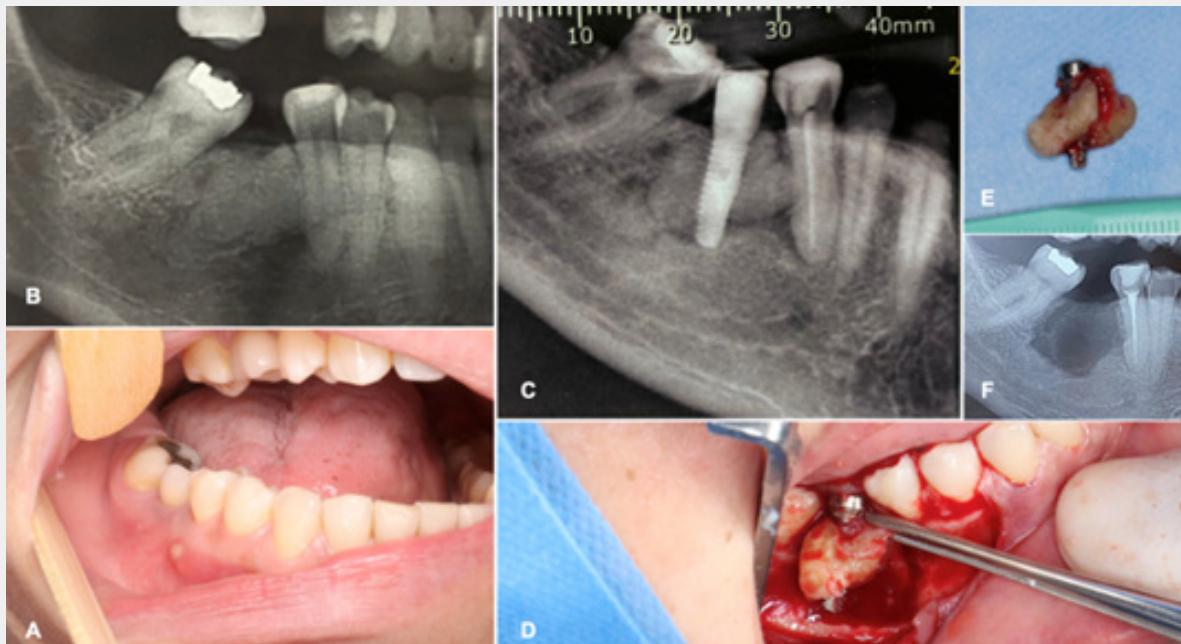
Infected focal COD presenting a gingival fistula. A, Intraoperative fistula located adjacent to the lower right second premolar with purulent discharge. B, Initial panoramic radiograph demonstrating a well-defined, asymptomatic radiopaque lesion in the region where the dental implant (DI) was installed. C, CBCT panoramic reconstruction showing the presence of a hyperdense lesion surrounded by a hypodense halo after dental implant placement, leading to secondary infection. D,E Both the lesion and the DI were removed under general anesthesia. F, Latest radiographic follow-up demonstrating bone healing and absence of residual lesion or infection.
